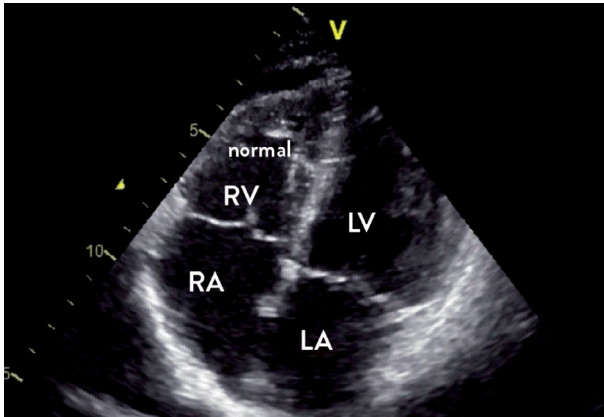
Echocardiography after heart transplantation; RA = right atrium; RV = right ventricle; LA = left atrium; LV = left ventricle.
